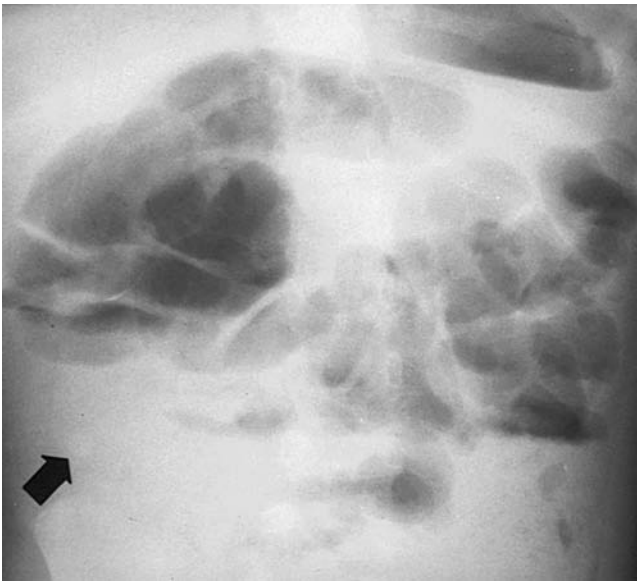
Perforated appendicitis with abscess and fecalith. The upright abdominal roentgenogram shows numerous dilated loops of bowel and a calcified fecalith (*arrow*). Note that the space between the individual loops indicates the presence of intraperitoneal fluid.
